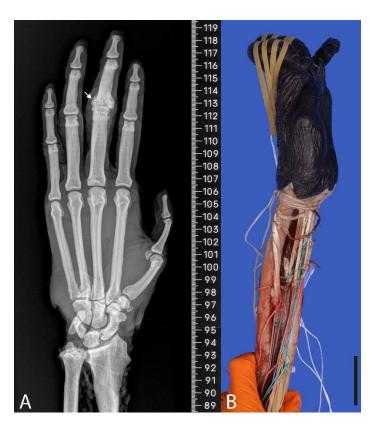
A. X-Ray of the female chimpanzee left hand used in experiments. Arrow: grossly consolidated fracture at the dorsal base of the middle phalanx. The fifth metacarpal head is markedly smaller than the load bearing metacarpals MC2-MC4.
